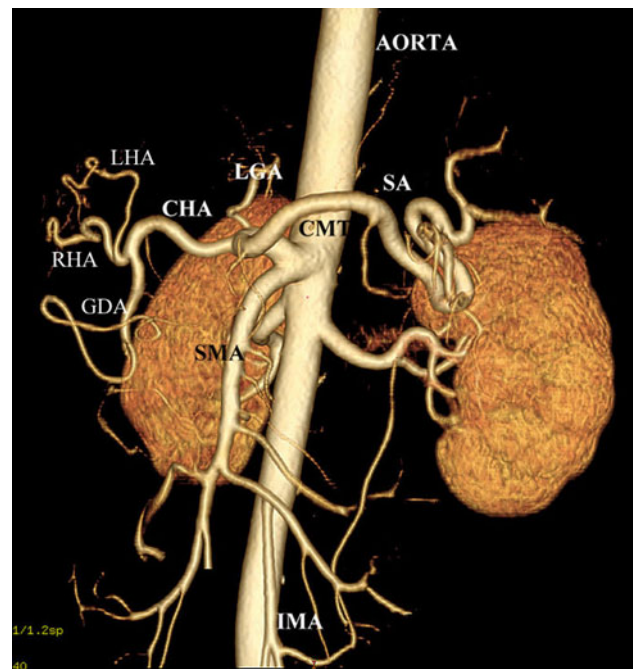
Three-dimensional volume rendered CT image showing the celiacomesenteric trunk (CMT). CMT divides into celiac artery and superior mesenteric artery (SMA). Common hepatic artery (CHA), splenic artery (SA) and left gastric artery (LGA) are seen arising from celiac artery. Inferior mesenteric artery (IMA) is also seen. RHA right hepatic artery, LHA left hepatic artery, GDA gastroduodenal artery
